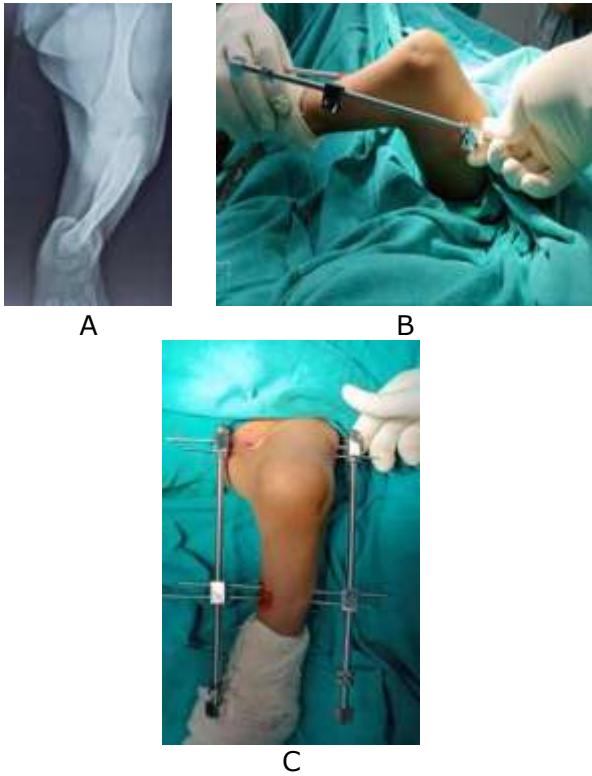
A, B & C Pre op Xray and intra op picture
